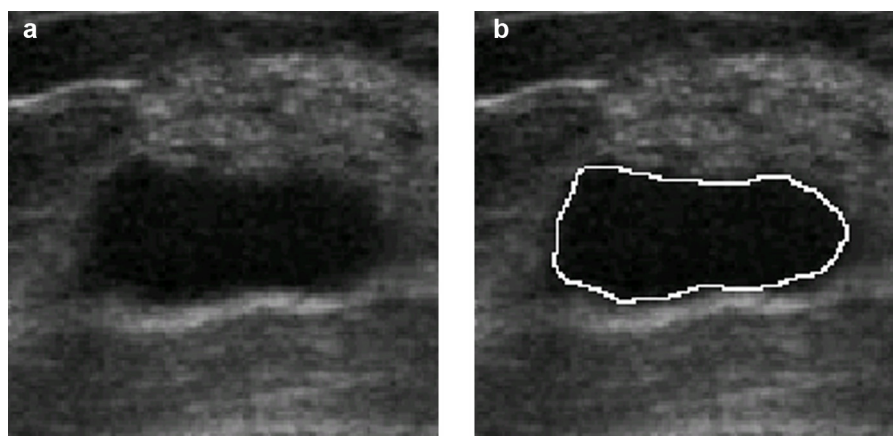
An example of a malignant tumor that was classified correctly by the proposed CAD algorithm but misclassified by the conventional CAD method. Among six predicted BI-RADS findings of this tumor, there were five benign findings: oval, parallel, microlobulated, abrupt interface, and no posterior acoustic features. Hypoechoicity was the only malignant finding that made this tumor to be classified as malignant in the diagnostic algorithm. The malignancy score of this tumor is 0.5 in the diagnostic algorithm. (a) The original sonographic image and (b) the contour outlined for feature extraction.
